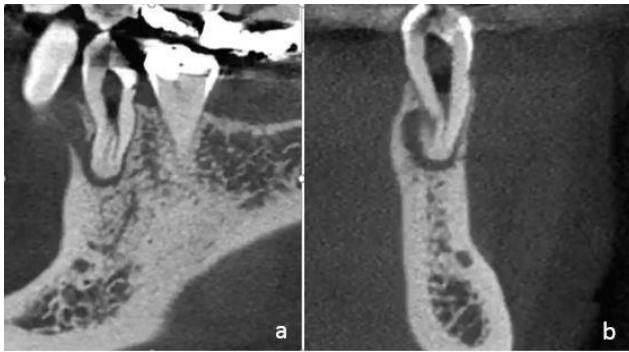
A) Sagittal view of CBCT shows the bifurcation of canals in middle third; B) Coronal plane of CBCT shows root depression located in the buccal surface
